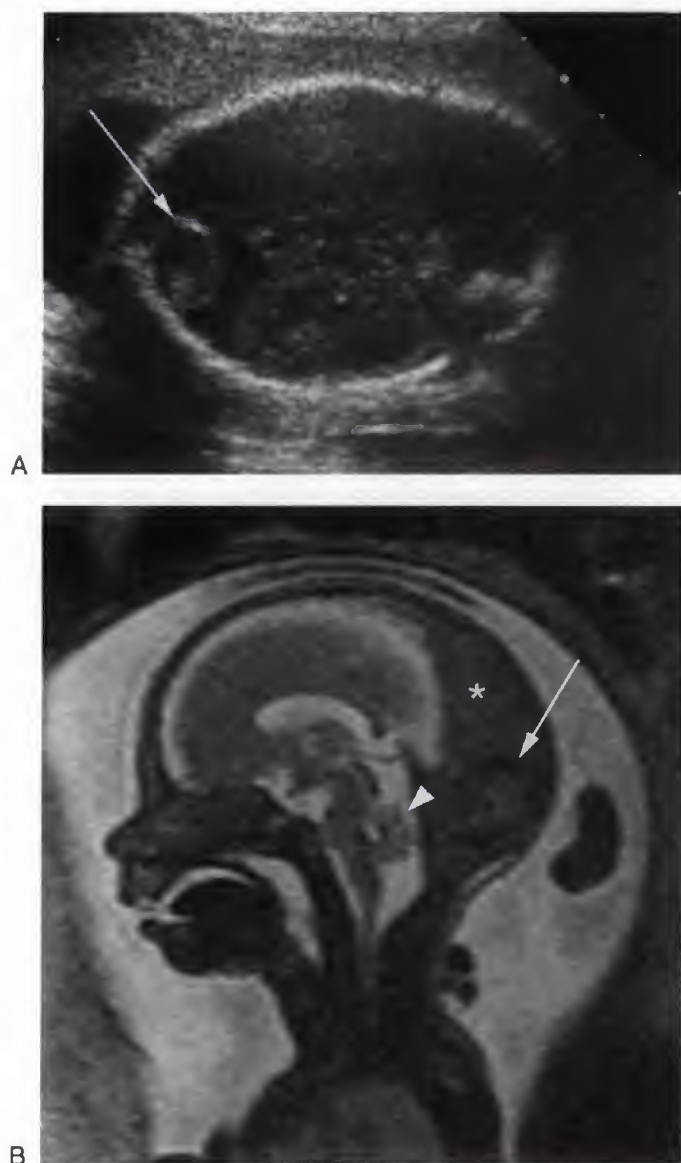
Ventriculomegaly at 19 weeks' gestational age by ultrasound with kinked midbrain by MRI. Sagittal T2-weighted MR shows marked ventriculomegaly and an abnormal configuration of the brainstem with a posterior kink (arrowhead) at the pontomesencephalic junction and an anterior kink (arrow) at the level of the fourth ventricle. The cerebellar vermis is hypoplastic. This type of abnormality is important because it indicates an early severe insult to the brain.
